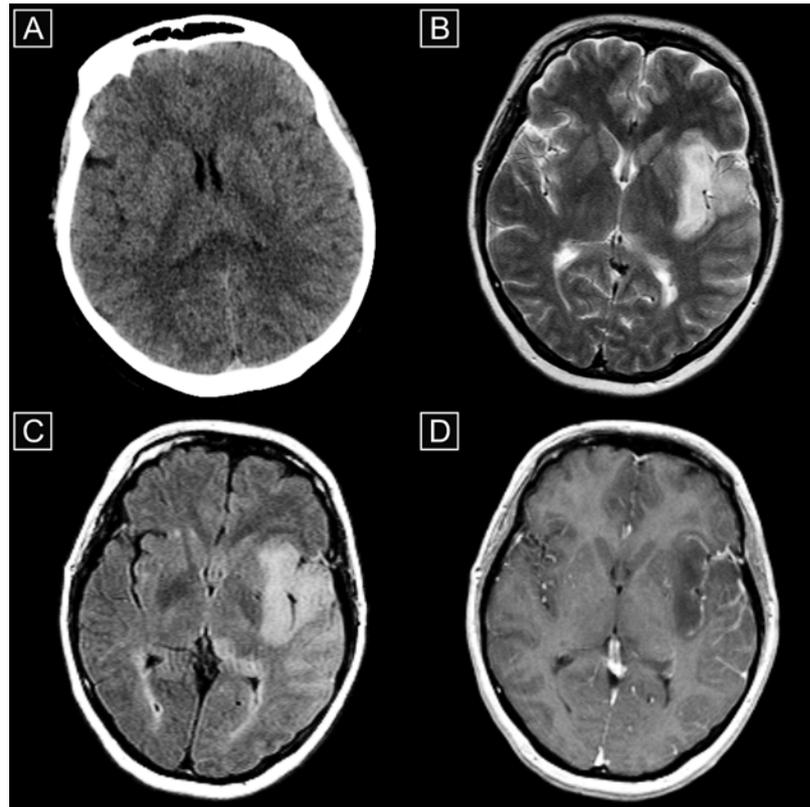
a-d. Lesions in acute phase of HSE. CT scan shows only a delicate asymmetry of lateral sulci (a). A wide hyperintense area on T2-weighted images (1.5T, TR/TE=5200/105) with the mass effect including the left temporal lobe insula except basal ganglia (b). On FLAIR sequence (TR/TE=8000/120) the extent of lesions and hyperintense lesion in the left thalamus well seen (c). Dilatation of insular cortex with gyral contrast enhancement on T1-weighted images (TR/TE=585/15) (c, d).
